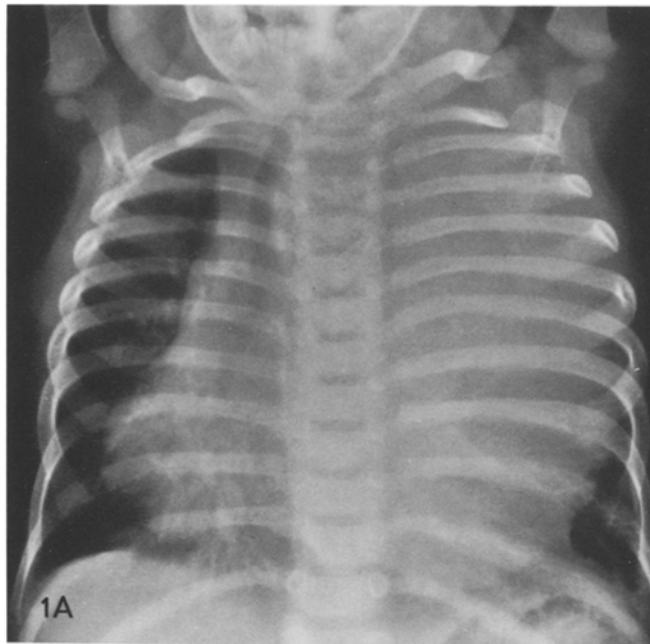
A Frontal chest roentgenogram showing left chest mass displacing cardiac and mediastinal structures to the right. B Lateral chest roentgenogram demonstrating mass to occupy anterior mediastinum
